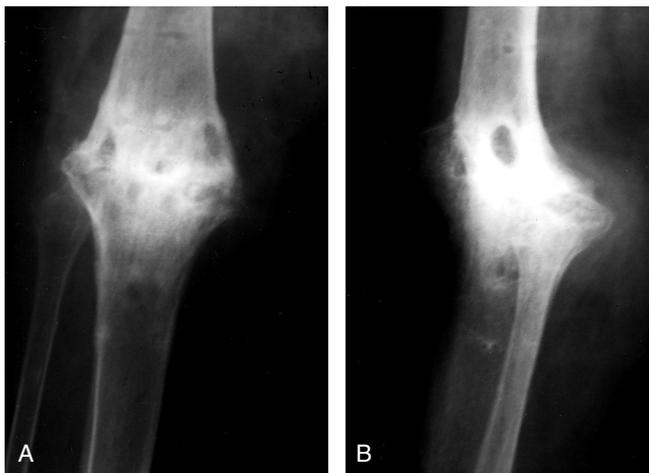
(A) Anteroposterior and (B) lateral radiographs of the same patient after Ilizarov frame removal showing a successful knee fusion.
